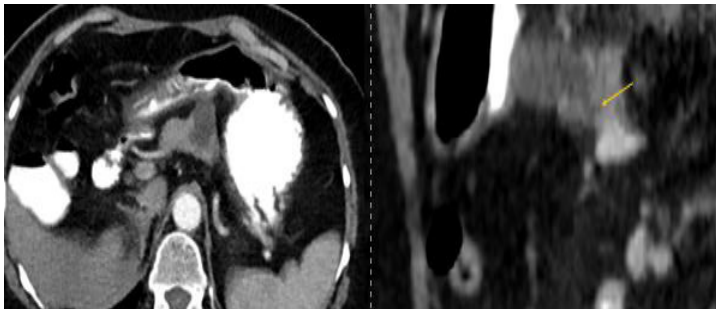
A female patient of 72 years old with a pseudocyst. The axial CT image shows a well-defined hypodense collection, and it is observed that the cystic lesion communicates with the pancreatic duct (arrow).
